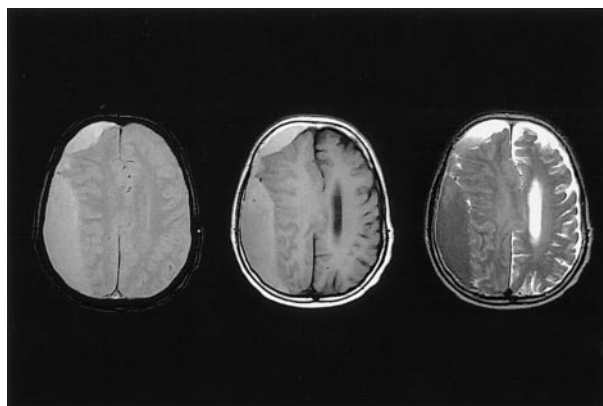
MR image of a 75-year-old man with homogenous and monolayer multilobule hematoma classified as type B; (left) T_2^* -weighted image, (center) T_1 -weighted image, (right) T_2 -weighted image
